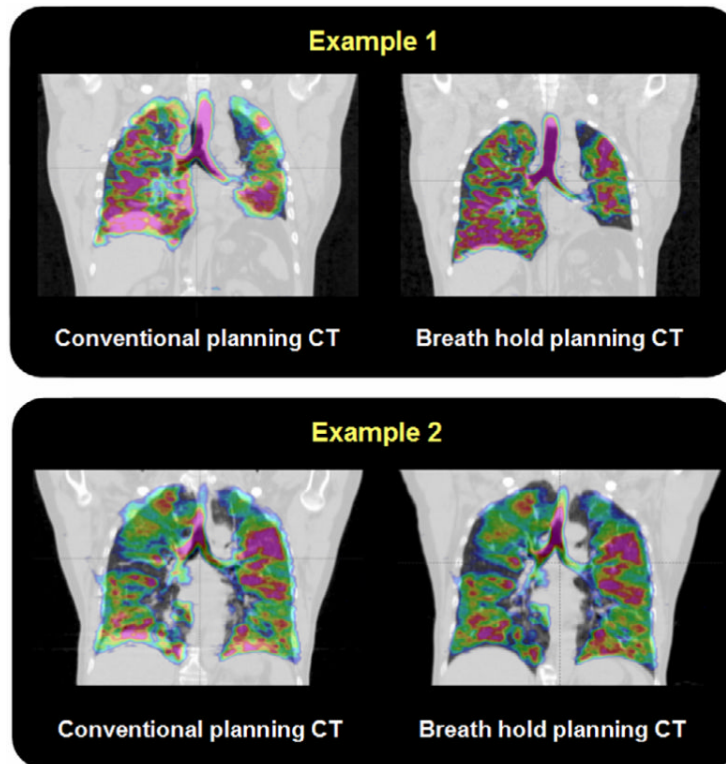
Two examples of registered coronal hyperpolarized ^3He -MRI (colour) displayed fused with radiotherapy treatment planning conventional, free-breathing CT (left) and inspiration breath-hold CT (right).
